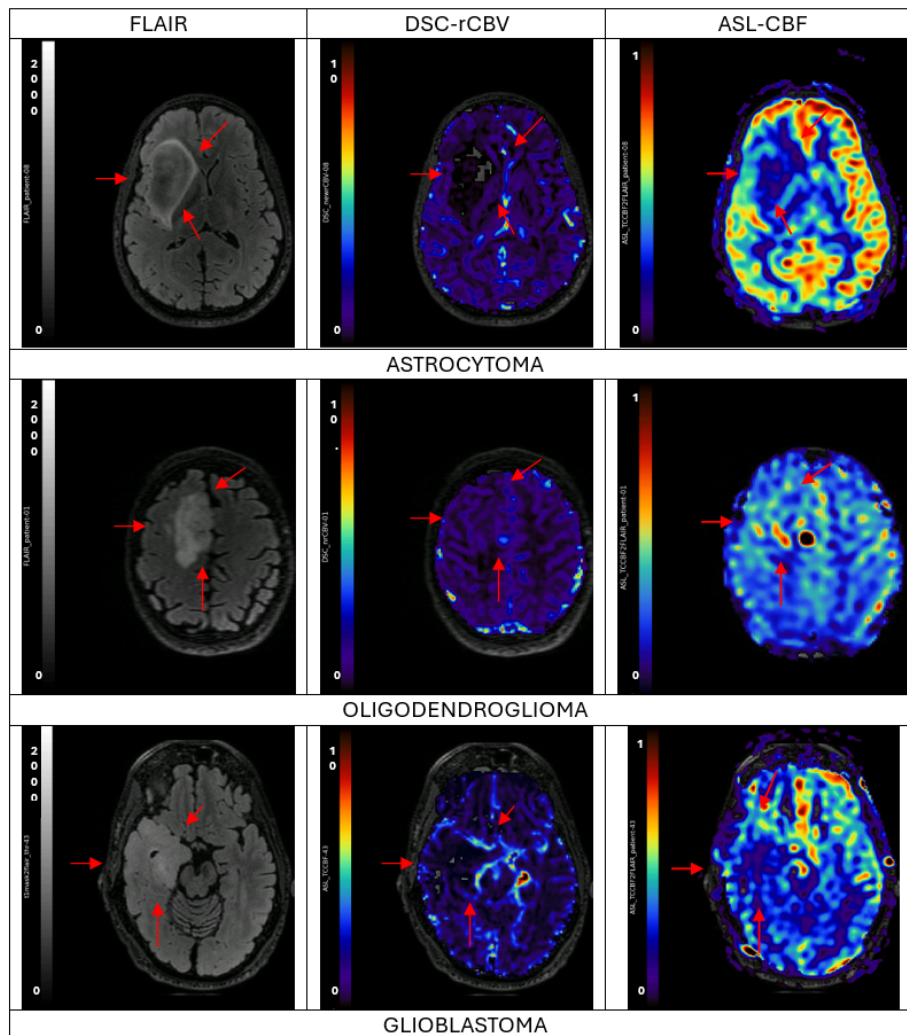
FLAIR, ASL, and DSC MRI appearance on different types of glioma, tumor areas are shown by the arrow
